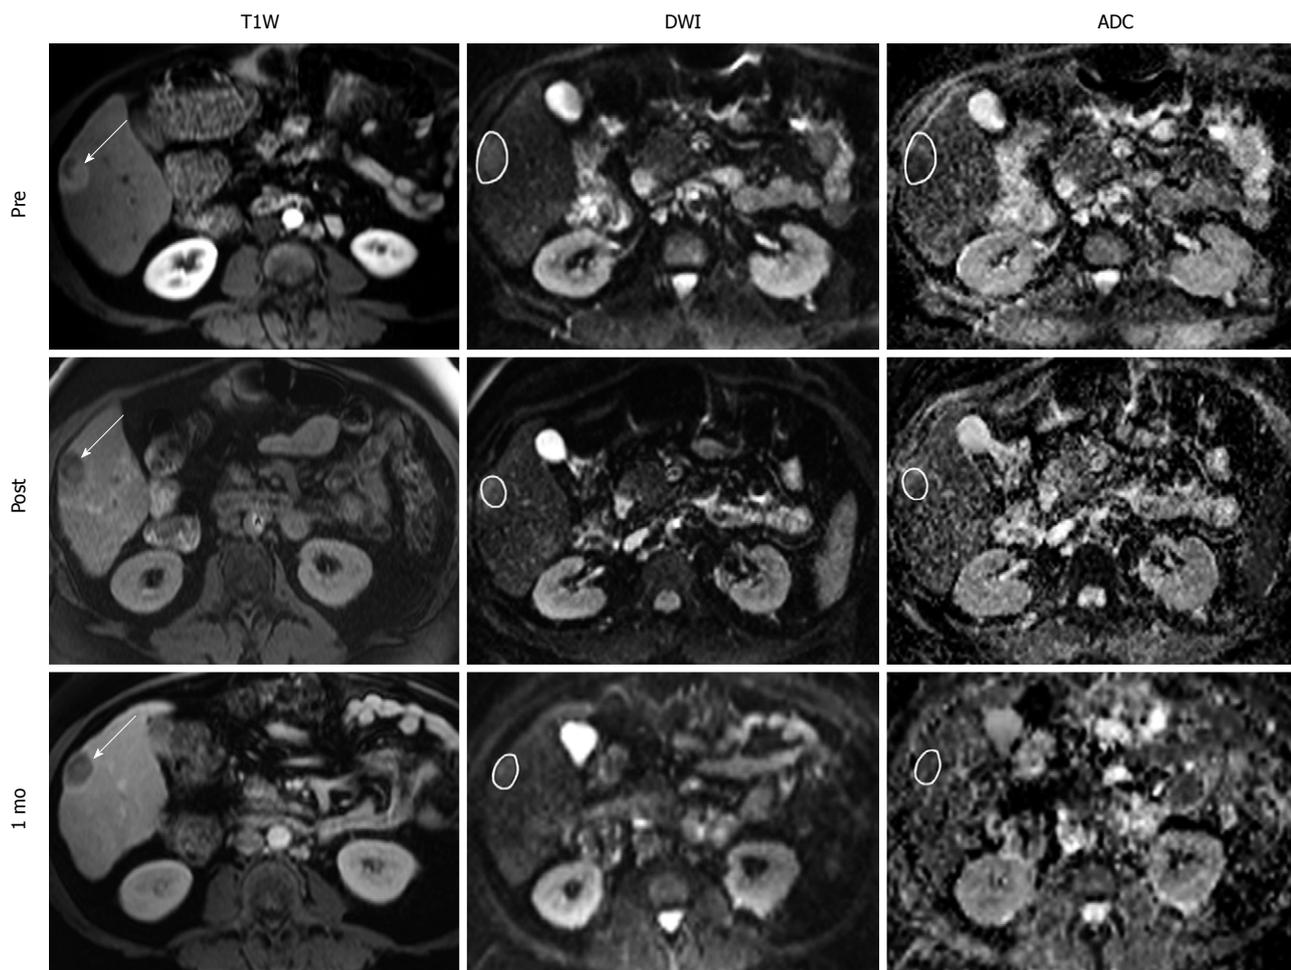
Representative T1W, DW, and ADC MR images from a 70 year-old man with right-lobe HCC secondary to autoimmune hepatitis. Images were acquired before, immediately after, and 1 mo after TACE. Arrows on the anatomical images indicate tumor location with sample ROIs drawn on the functional MR images. Intra-procedural ADC changed by 28.6%, which predicted a favorable EASL response at 1 mo. T1W: T1-weighted; DW: Diffusion-weighted.
